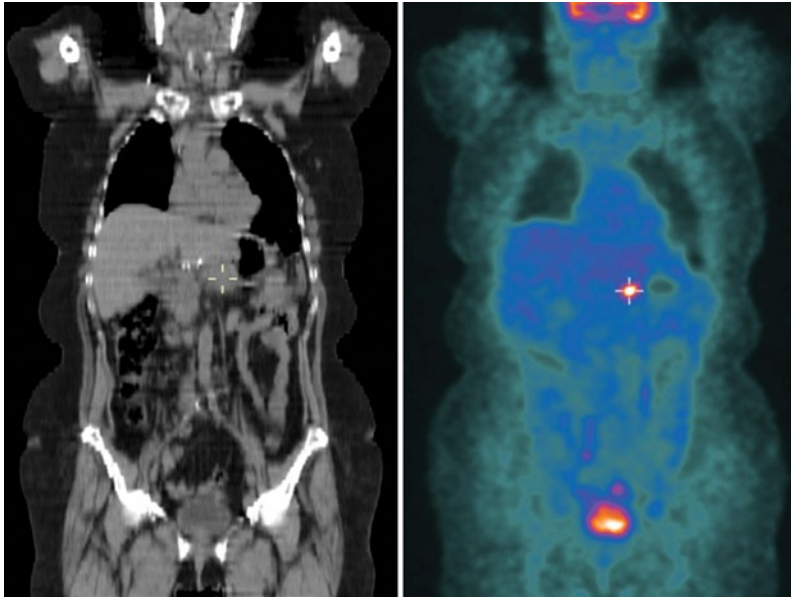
^{18}F -FDG PET/CT scan showing uptake near the stomach remnant 18 months after subtotal gastrectomy for locally advanced gastric cancer (pT3N1M0). Surgical exploration revealed localized peritoneal carcinomatosis
